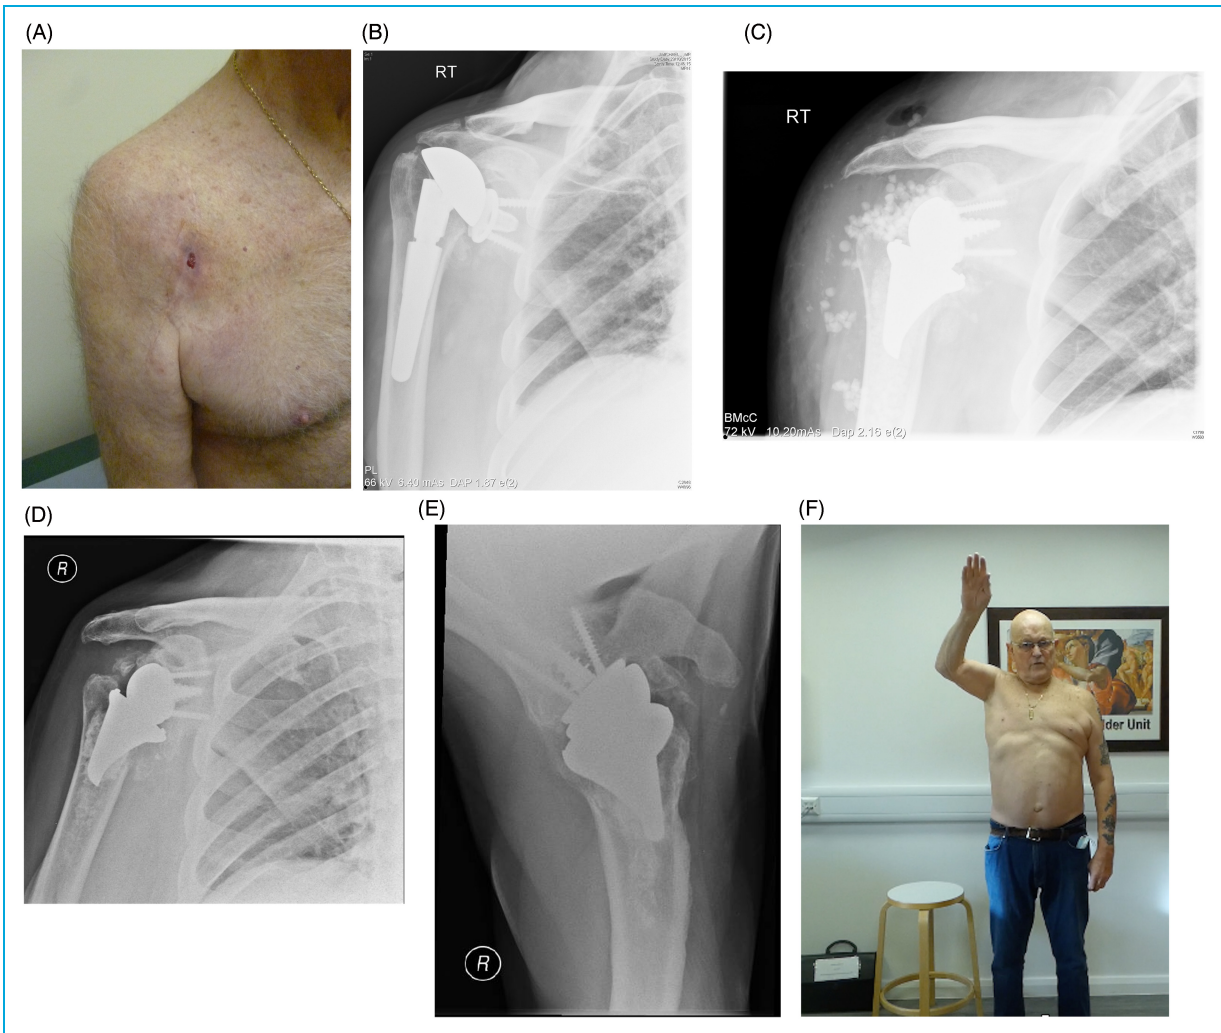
(Patient 5). (A) 67 years with hematogenic infected stemmed Lima TSA (Staph. Aureus) with fistula. (B) X-rays infected stemmed Lima TSA. (C) Immediate post-operative X-rays with the stemless metaphyseal stemless rTSA with Stimulan beads. (D, E) X-rays at last follow-up, over 10 years after the revision TSA, showing formation of new bone in the metaphysis and the medullary canal following the bone graft substitute + Stimulan impaction. (F) Clinical outcome at last follow-up, over 10 years after the revision TSA.
